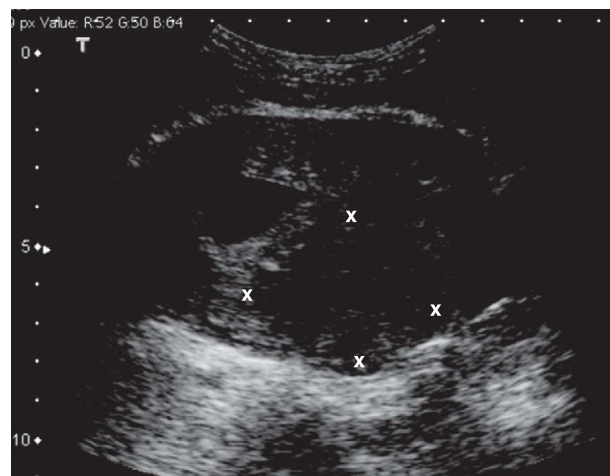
Ultrasound image of a uterine fibroid (within x's). (Courtesy of Robert Reardon, MD, Hennepin County Medical Center; used with permission.)
